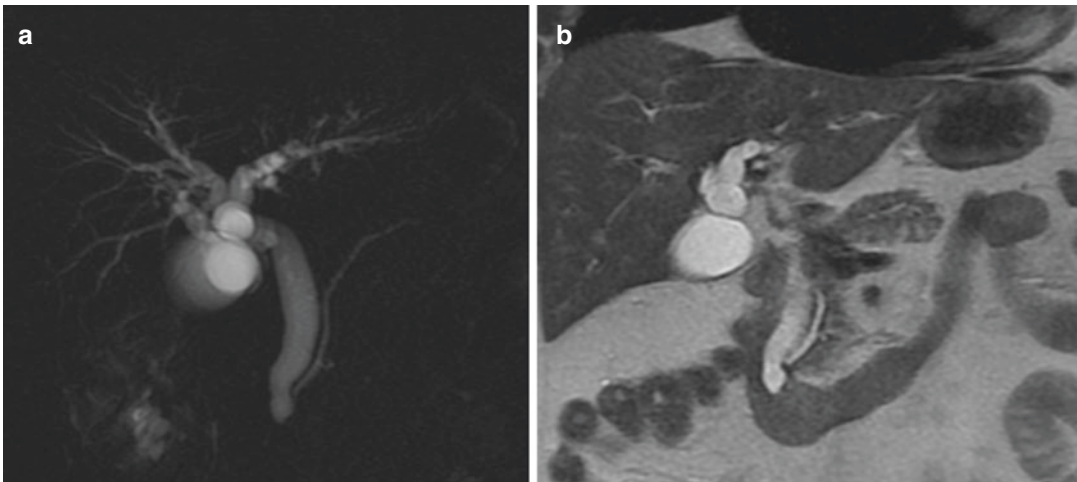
Ampullary tumour with upstream abrupt dilation of the CBD on (a) 2D-MRCP image and on (b) coronal T2-weighted image
